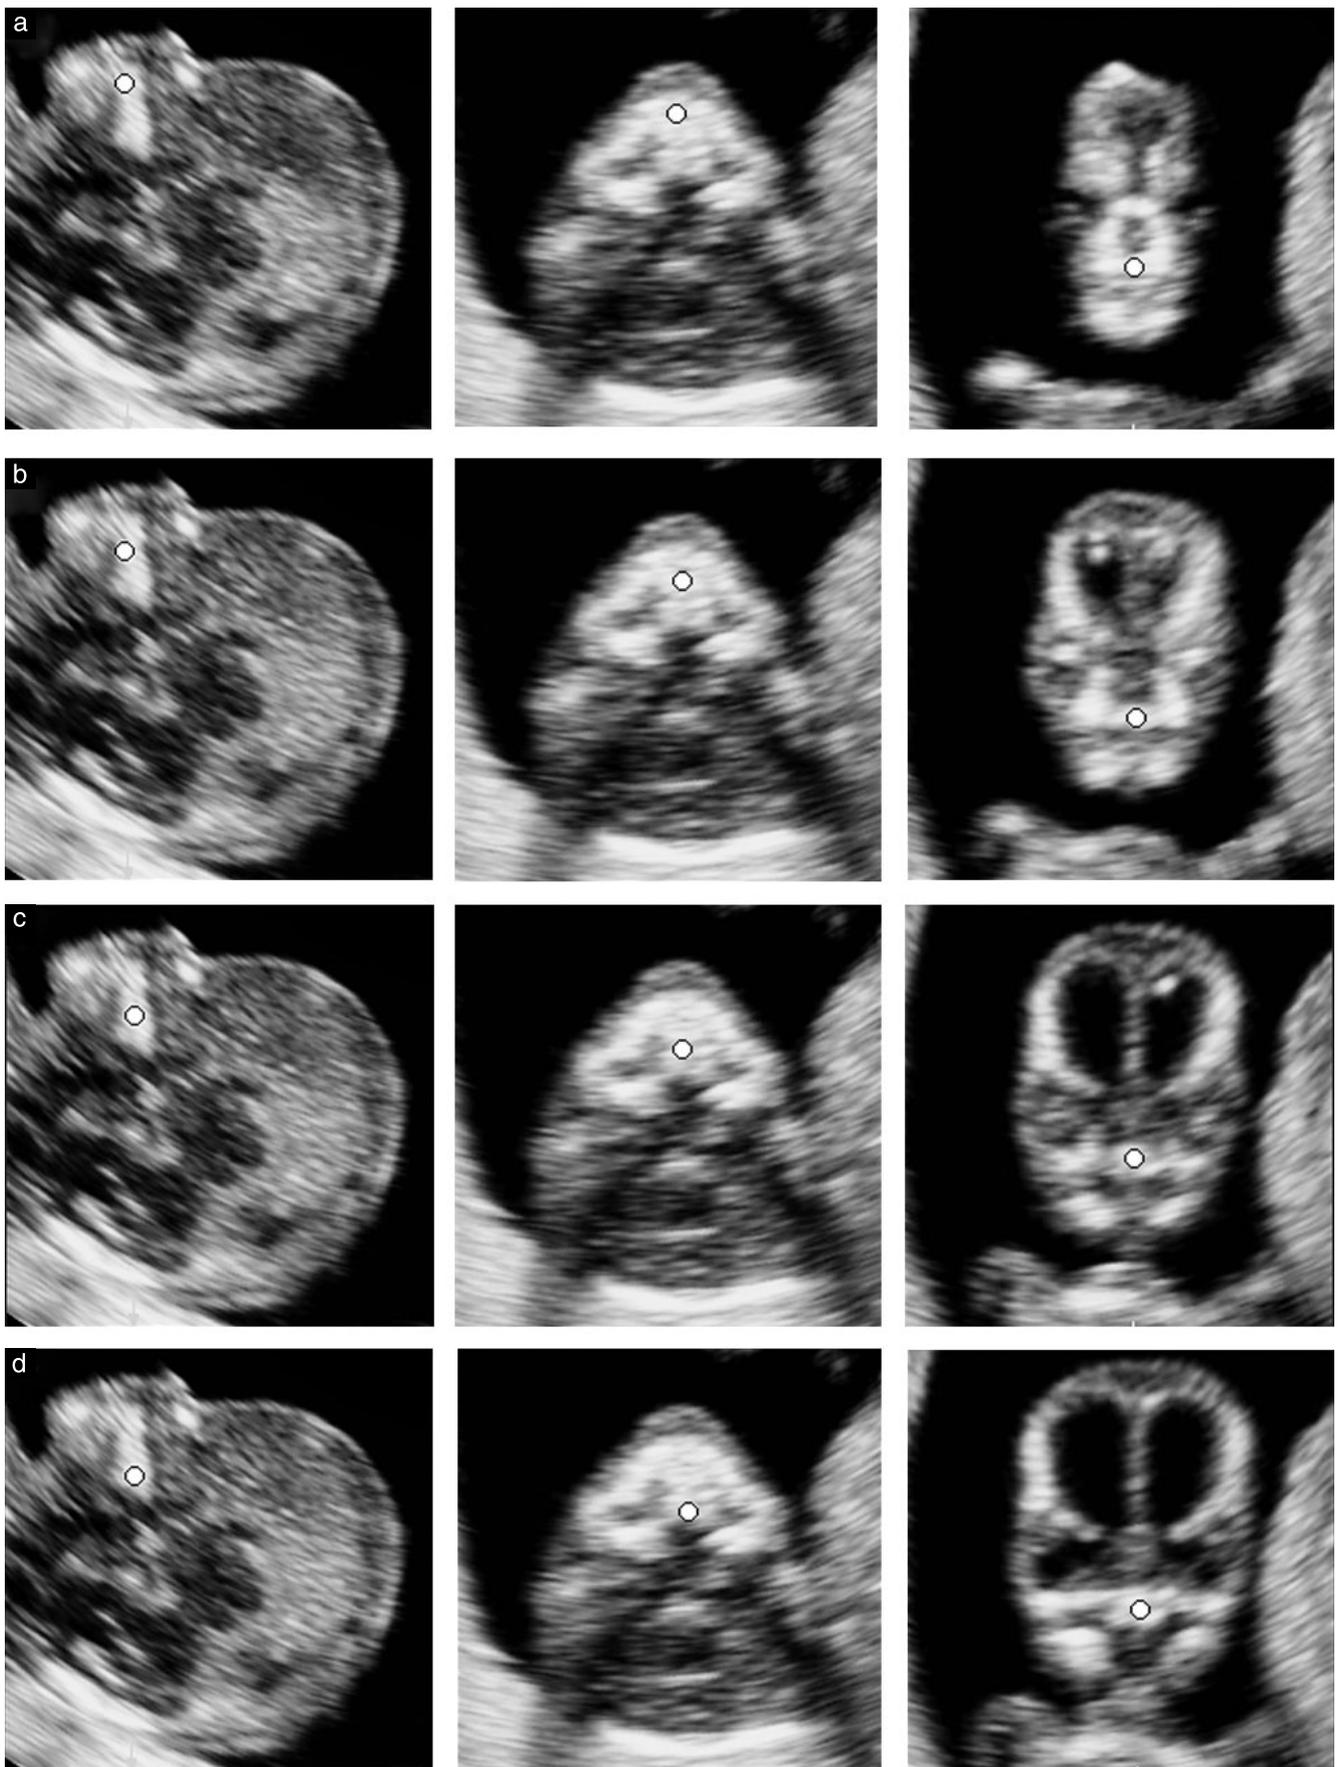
Sonographic views obtained from multiplanar orthogonal planes of the face in a normal fetus at 12 weeks' gestation. Left, middle, and right panels represent the mid-sagittal, transverse and coronal planes, respectively. The reference dots show the intersection of the orthogonal planes, which have been moved to progressively deeper planes to show the relationship between the retronasal triangle and the palate (a–d). Note that the retronasal triangle is obtained only at the level of the primary palate, particularly at the level of the alveolar ridge (a, b).
